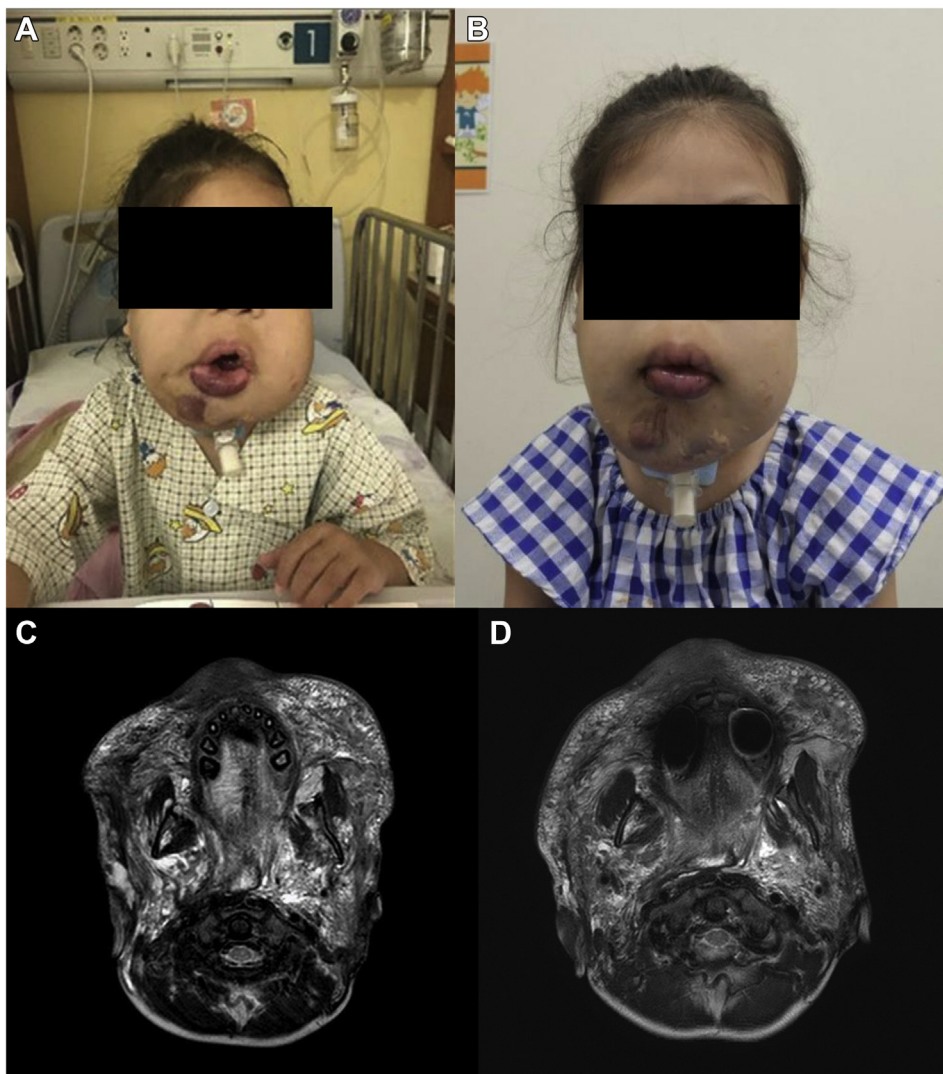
Clinical photographs of patient 2 showing a cervicofacial lymphovascular malformation before the initiation of sirolimus (A) and the interval decrease in the lesion size, with a decreased mucosal lesion after administration of sirolimus (B). Axial T2-weighted magnetic resonance imaging (MRI) of patient 2 at the beginning of therapy (C) and at 10 months of sirolimus administration (D).
